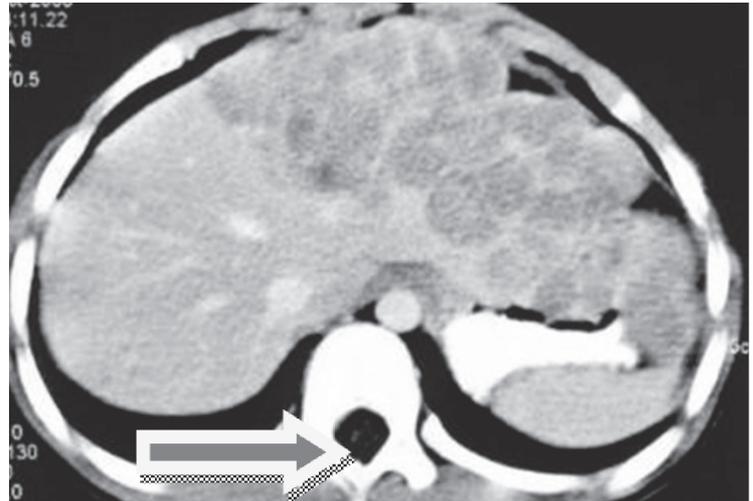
CT-Scan image showing heterogenous mass, and calcifications in the right lobe and left lobe of the liver. The mass is Hypoattenuated compared to surrounding liver. Necrotic and hemorrhagic areas were not seen.
